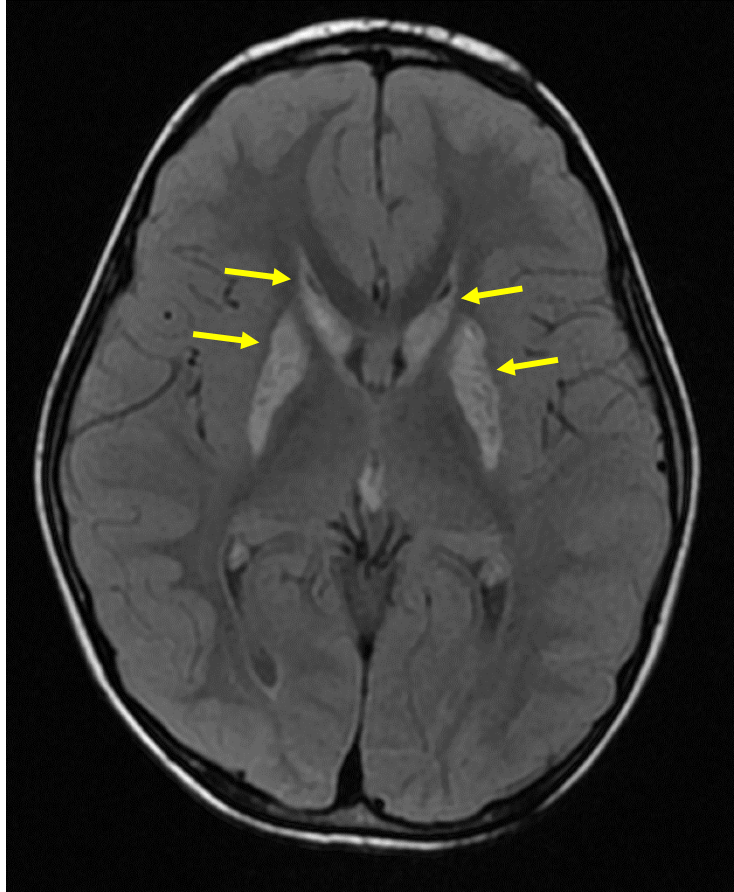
Brain MRI neuroradiological image for patient 7-I
